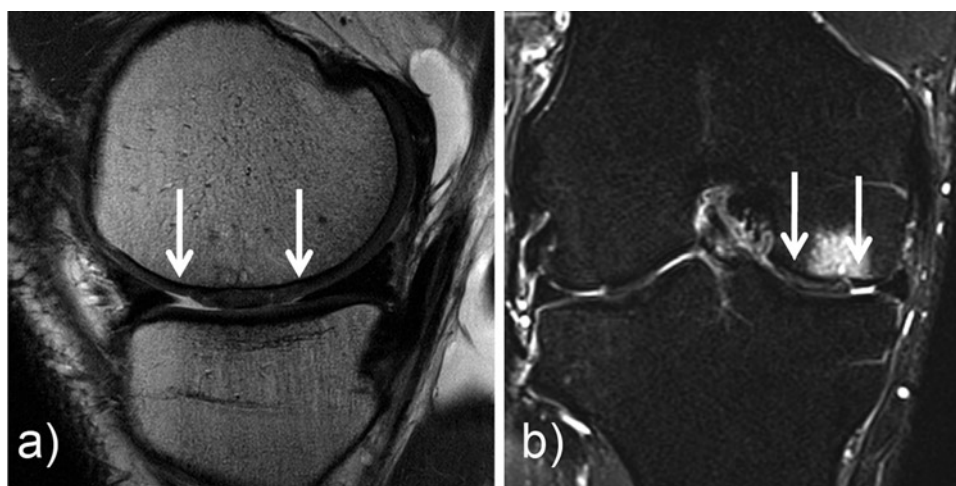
Conventional high-resolution MRI of a 48-year-old male patient 24 months after matrix-associated chondrocyte transplantation (MACT) (arrows). (a) Sagittal PD-TSE (TR=2,400 ms/TE=28 ms; flip angle=160°) with ultrahigh in-plane (0.23×0.23 mm) resolution
